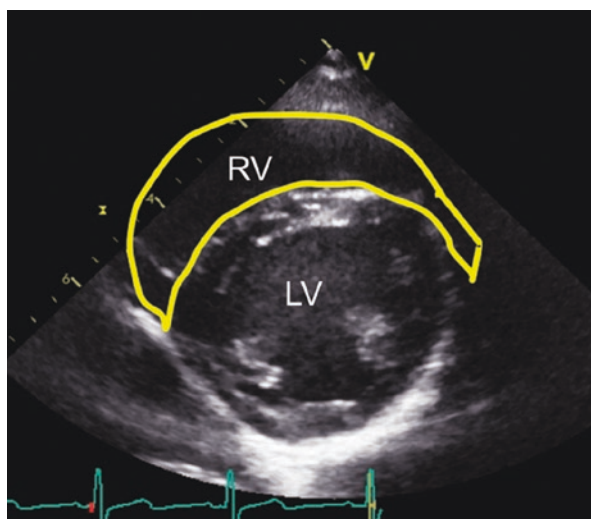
Parasternal short axis view at the height of the papillary muscle
